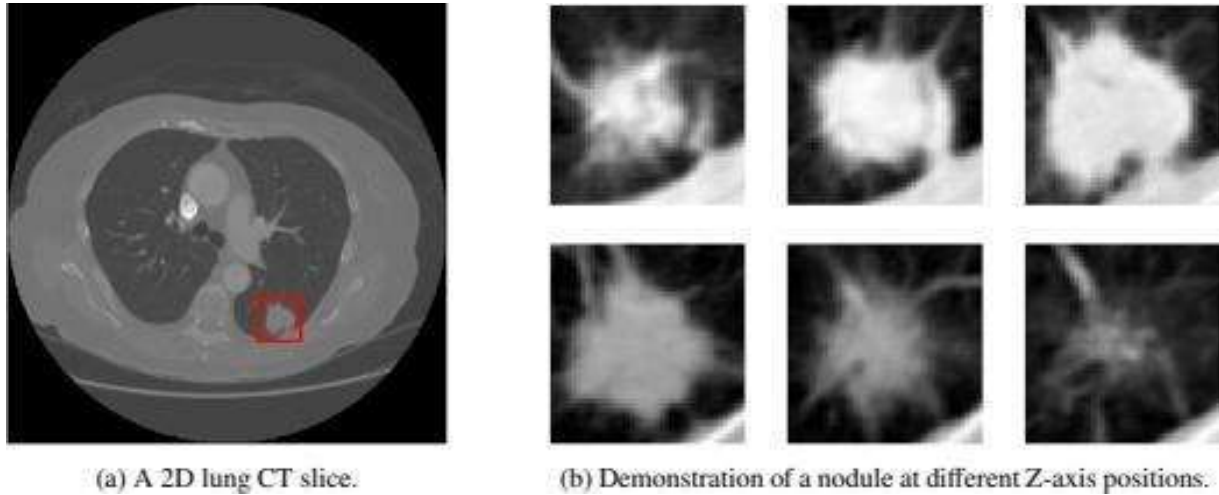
Represents sample CT image in 2D and 3D space
